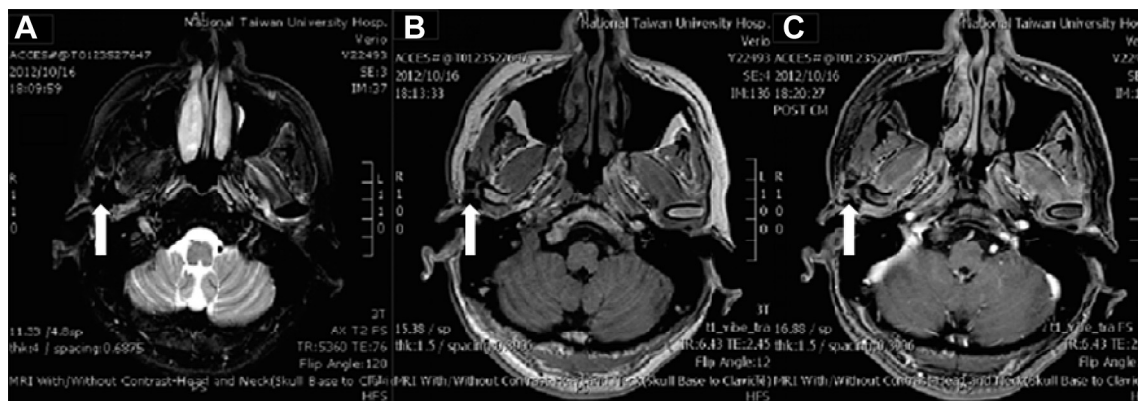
Magnetic resonance imaging findings. The mass, measuring 2 cm in size, adjoining to the mandible condyle was hyposignal in T2W (A) and isosignal in T1W (B). Heterogeneous enhancement of the mass in T1W with contrast (C).
